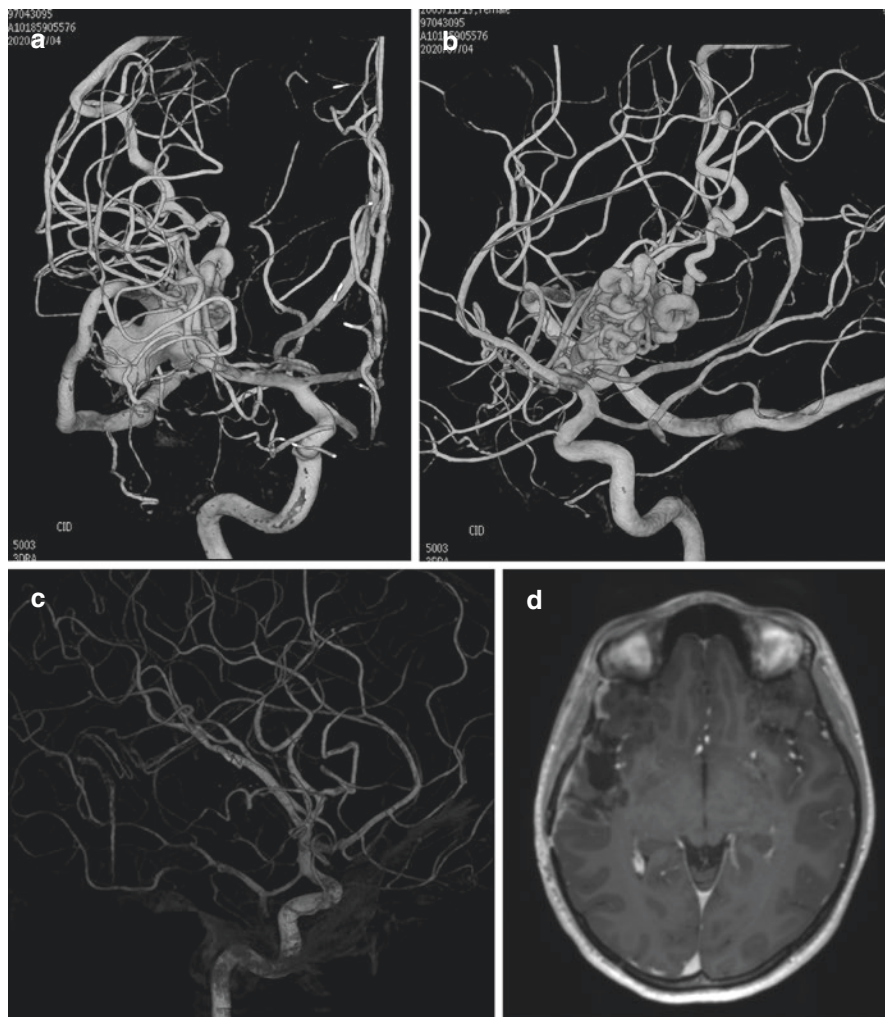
14-year-old girl with an episode of sudden headache without loss of consciousness. CT revealed a subarachnoid hemorrhage and a DSA showed a giant aneurysm (25 mm) in the Sylvian fissure (a) with a small right-sided insulo-temporal AVM (Spetzler-Martin grade 1) medial to the giant aneurysm (b). She underwent emergency surgery with clipping and resection of the aneurysm, followed by a complete resection of the AVM, as verified by a postoperative DSA (c). 6 months after surgery, she was mRS 0 without any sequelae and an MRI showed no residual lesion (d)
